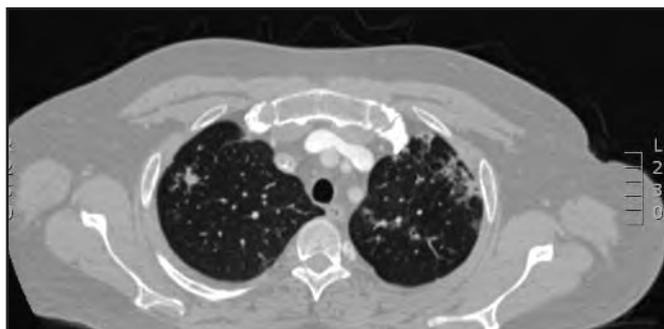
The patient's CT scan of thorax showing right lung nodules and ground glass appearances.
